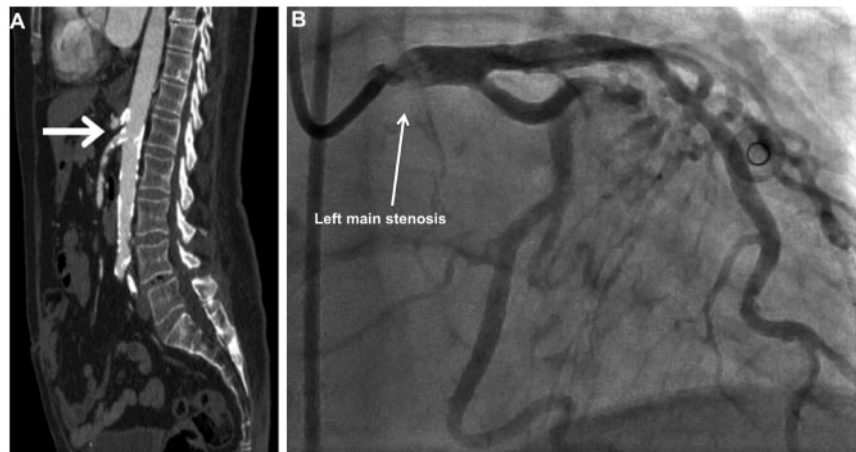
(A) Computed tomography scan showing a calcified aorta, and coeliac and superior mesenteric arteries. (B) Coronary angiogram showing left main stenosis.
